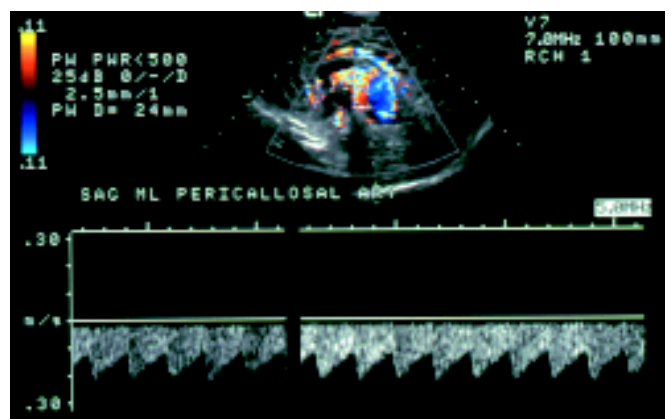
Doppler sagittal image of malformation.
